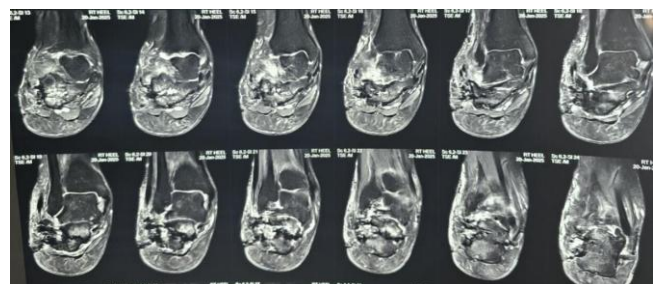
Coronal section of calcaneum MRI showing classic features of chronic osteomyelitis: marrow edema, cortical breaching, and a fluid collection with a sinus tract of 3.1 cm
